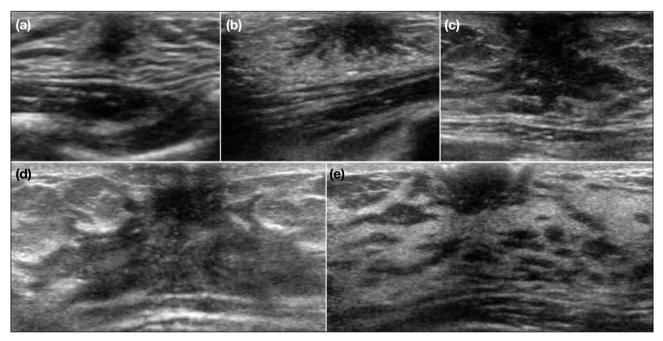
Ultrasound features of Tanner stages of normal breast development. (a) Stage I: III-defined echogenic retroareolar tissue. (b) Stage II: Echogenic retroareolar tissue with central stellate hypoechoic area. (c) Stage III: Central spider-like hypoechoic projections extending away from the retroareolar region, with surrounding hyperechoic glandular tissue. (d) Stage IV: The retroareolar hypoechoic central area persists, with enlargement of the periareolar hyperechoic fibroglandular tissue. (e) Stage V: Mature breast appearance with hyperechoic fibroglandular tissue and increased subcutaneous adipose tissue. The central hypoechoic area is absent.
